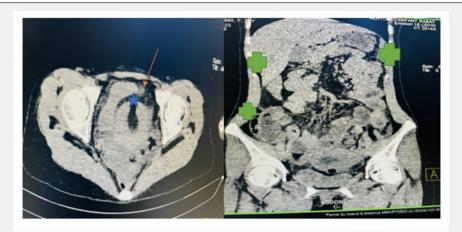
Abdominal and pelvic CT scan performed in helical acquisition in 3 mm thick section with mltiplanar reconstruction in parenchymal and bone window without injection of contrast medium allows to demonstrate a trans-mural, oblique, 48 mm long anterior body continuity solution () measuring 20 mm in diameter. Associated with an important infiltration of the fat in front of it containing pneumoperitpine bubbles due to anaerobic germs essentially () associated with a hemoperitoneum of medium abundance in the perihepatic, peri splenic and pelvic areas
